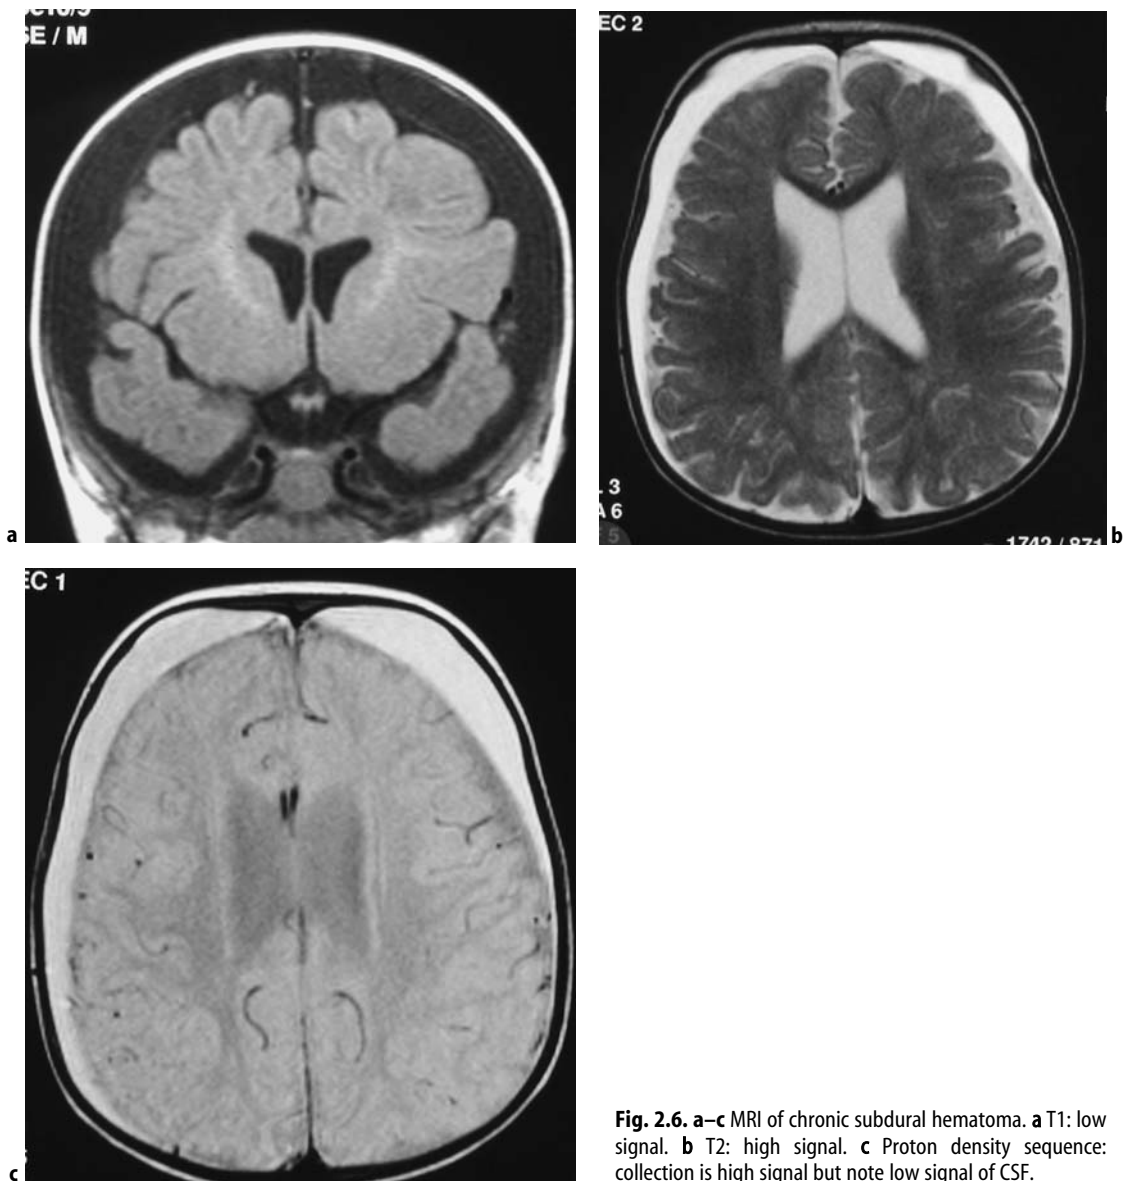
a–c MRI of chronic subdural hematoma. a T1: low signal. b T2: high signal. c Proton density sequence: collection is high signal but note low signal of CSF.
